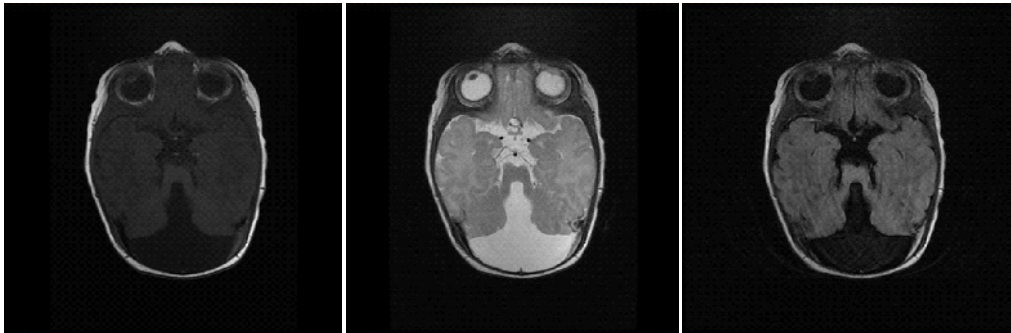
T1W, T2W and FLAIR images show aplasia of the vermis, thickening of the superior cerebellar peduncles and deepening of the interpeduncular sulcus (groove) "molar tooth appearance".
